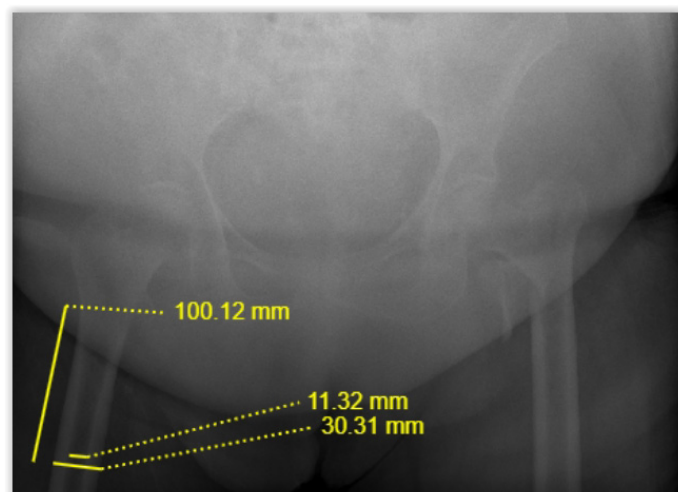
Sample measurement of cortical condition index (CTI) at the subtrochanteric level of the femur on AP X-ray of the pelvis. $CTI = (Total\ width - Medullary\ width) / Total\ width$
